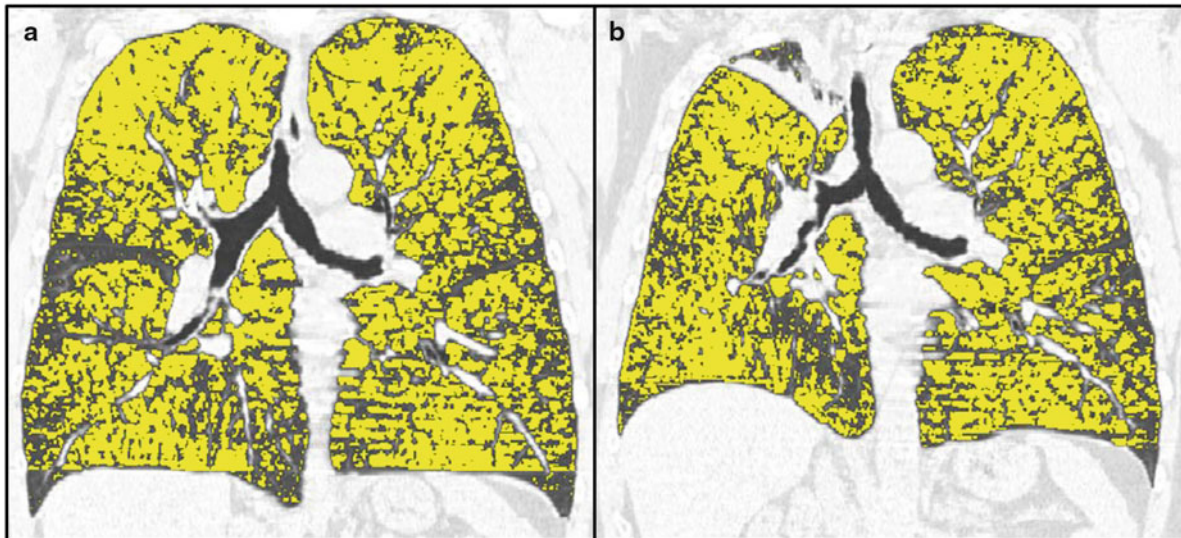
The 61-year-old male patient acquired 60 pack years and presented COPD IV (FEV1 0.5 l, 6-min walk test 150 m). CT revealed severe diffuse bilateral centrilobular emphysema (emphysema index 48%, 15th percentile -983HU). After endobronchial placement of three
